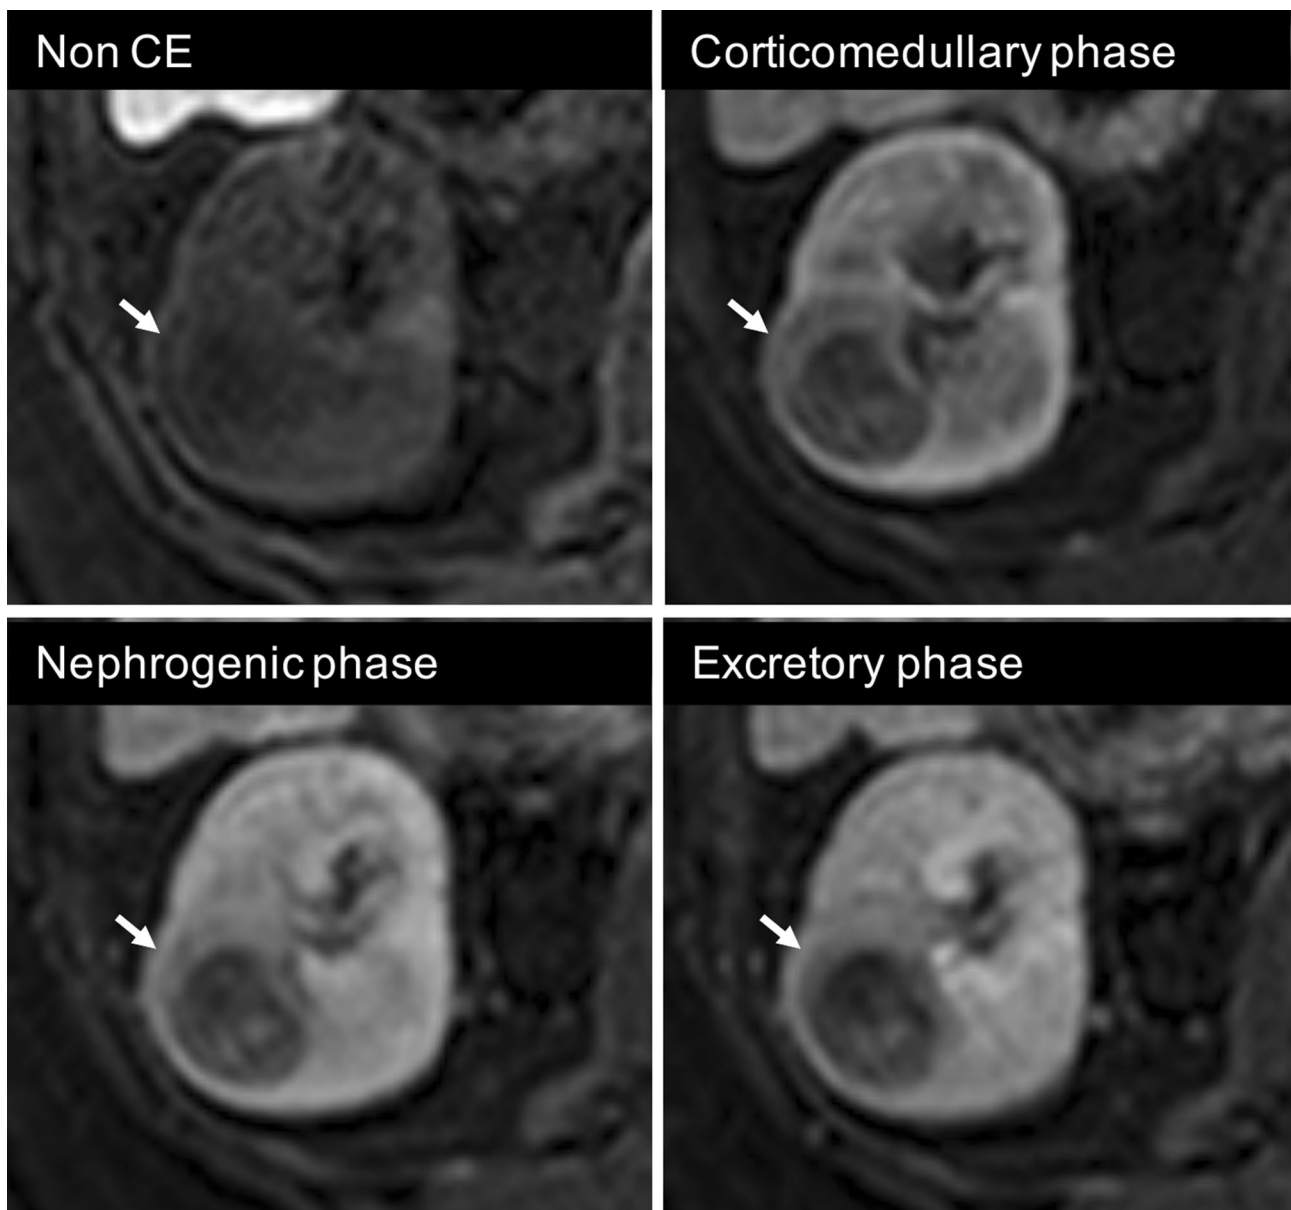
On contrast-enhanced MRI, the mass is not enhanced except for small nodular parts, and the rim of the mass displays pale enhancement (arrows)
